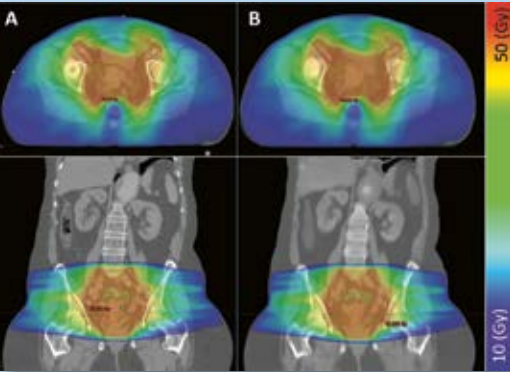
A) Dose plan calculated from CT-image. B) Dose plan calculated from PET/MR derived synthetic CT using AI.
